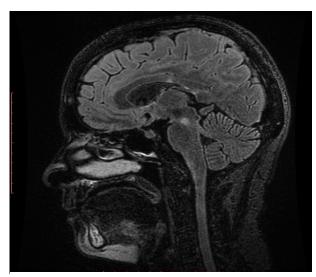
Sagittal FLAIR – shows the same unique brainstem lesion
